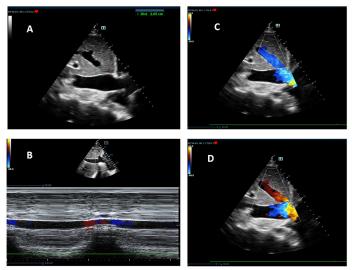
c.7. Dilated inferior vena cava (2.65 cm) (A) with reduced respiratory variability (B) and dilated suprahepatic veins with flow reversal revealed by blue (C) and red (D) color during cardiac cycle (2D, M-mode, color Doppler, subxiphoid and subcostal views).
